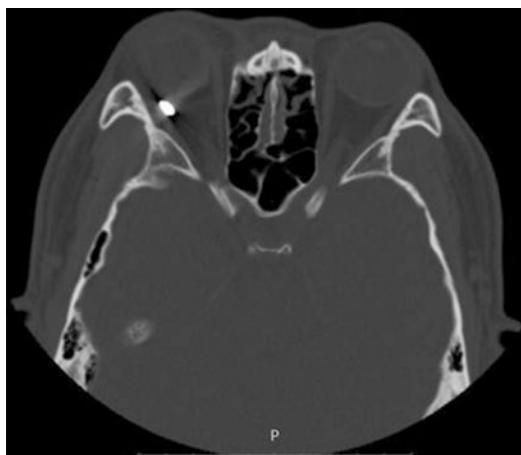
The CT scan acquired 18 h after trauma showing the roundish metal foreign body located just behind the posterior wall of the eye with air surrounded and the irregular shape of the eyeball
